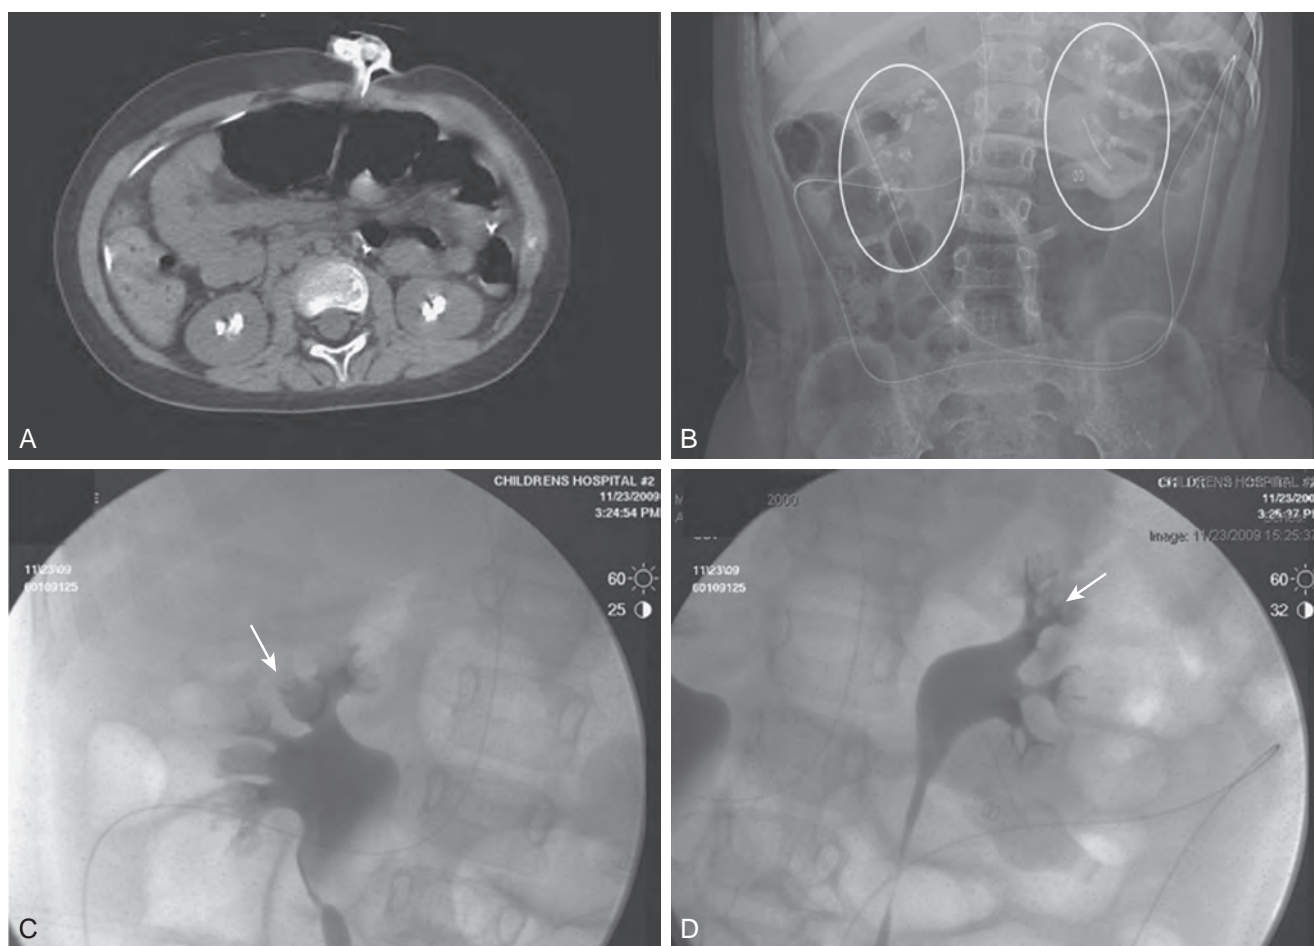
A 9-year-old boy with cerebral palsy and gross hematuria. Computed tomography scan demonstrated bilateral nephrolithiasis (A) thought to be staghorn calculi. Plain radiograph (B) and bilateral retrograde pyelograms (C and D) correlate to show nephrocalcinosis (white circles in B and arrows in C and D) reflective of medullary sponge kidney disease. Subsequent metabolic workup revealed renal tubular acidosis with hypercalciuria.
